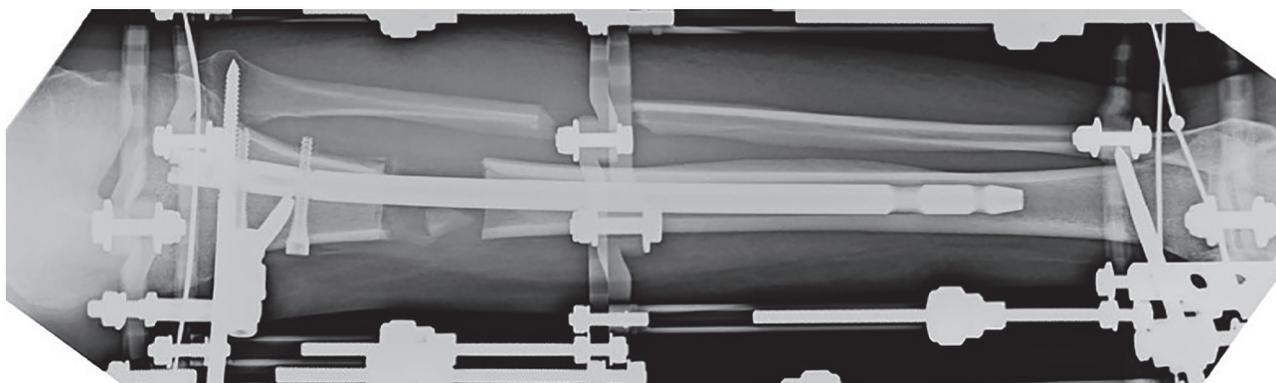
A contralateral x-ray of the same patient during the lengthening period is shown (left tibia).
